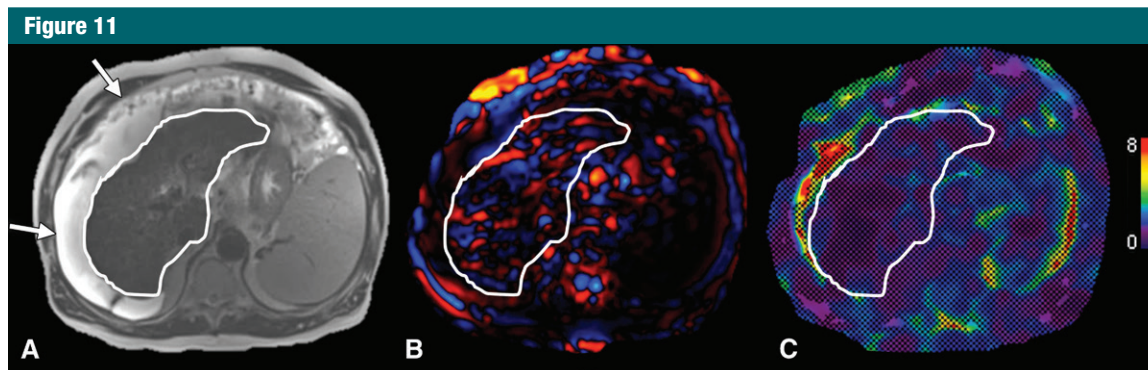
Images in a 57-year-old man with decompensated cirrhosis (secondary to chronic hepatitis C virus infection) and large ascites causing two-dimensional gradient-recalled-echo MR elastography failure. *A*, Transverse T2-weighted half-Fourier acquisition single-shot turbo spin-echo, or HASTE, image shows cirrhotic liver (liver contour outlined in white) and large ascites (arrows). *B*, Transverse wave image shows propagation in subcutaneous fat and fluid but disrupted waves in liver parenchyma, resulting in no reliable areas of stiffness measurement on, *C*, transverse elastogram.
